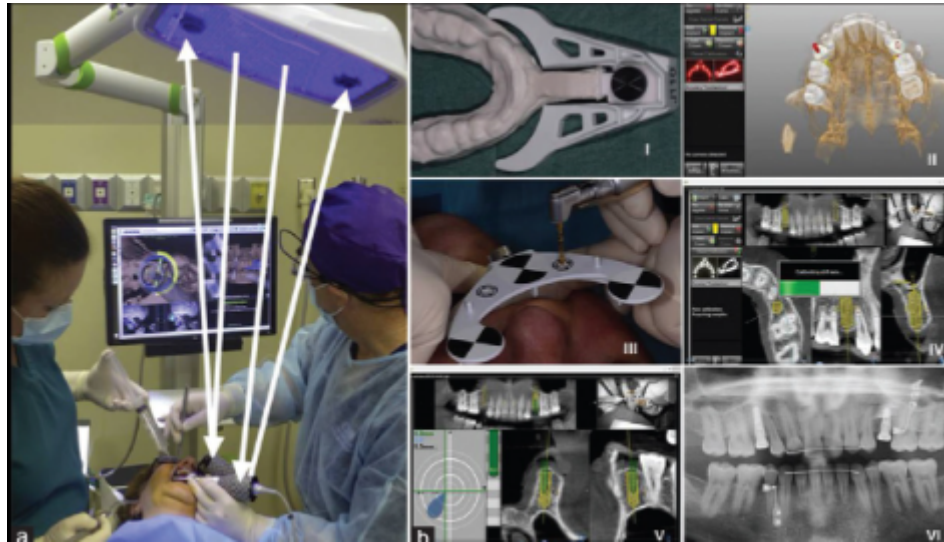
Dynamic navigation system. (a) Components: Patient jaw attachment, handpiece attachment and a system consisting of a camera, overhead blue emitting lights, computer and sensor; (b) Surgical procedure: I- Thermoplastic stent attaches with the remaining teeth in the arch using the radiographic marker; II-Digital planning; III and IV-Preoperative planning; V- Osteotomy drilling by viewing on the screen; VI- Postoperative image after implant placement
